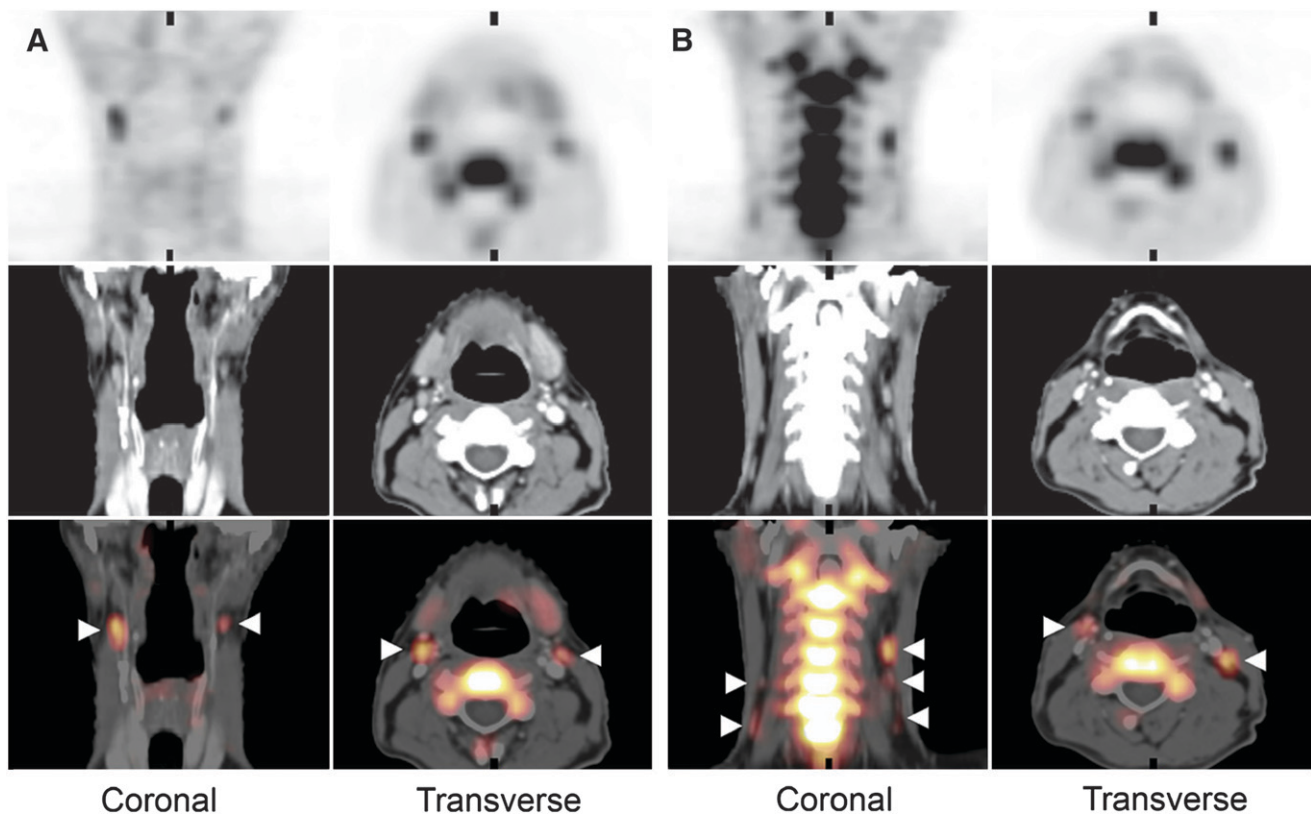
^{18}F -FLT PET/CT images of patient 9 (pT2pN0M0 oral cavity carcinoma). Top panels show PET images, middle panels show CT images, and bottom panels show fusion of both image modalities. Cervical lymph nodes with increased ^{18}F -FLT uptake are found bilaterally in level II (A, arrowheads) and in levels III and IV (B, arrowheads). All lymph nodes detected with ^{18}F -FLT in this example were false-positive for metastasis, due to uptake in proliferating B-lymphocytes in reactive germinal centers.
